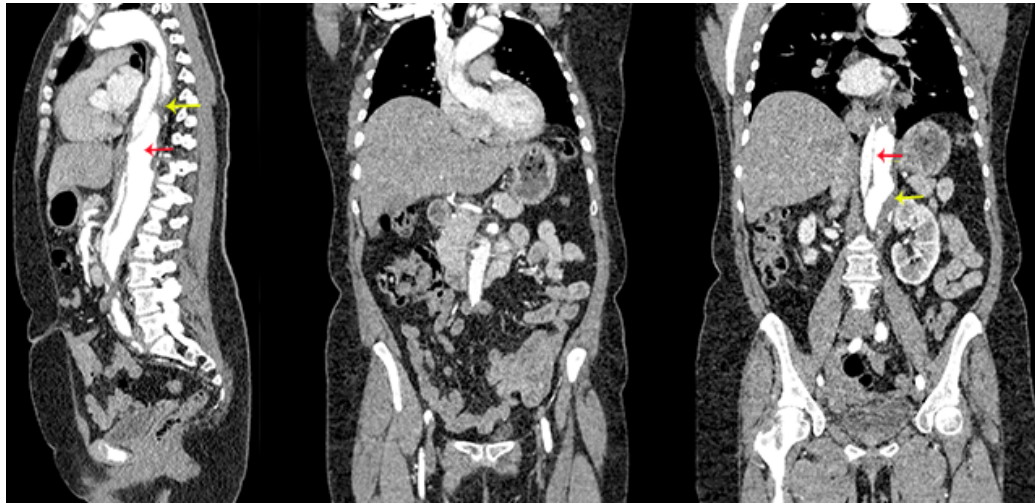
PATIENT 3. A: PRE-OPERATIVE CT SCAN WITH RED ARROW HIGHLIGHTING THE TRUE LUMEN AND THE YELLOW ARROW HIGHLIGHTING THE FALSE LUMEN.
